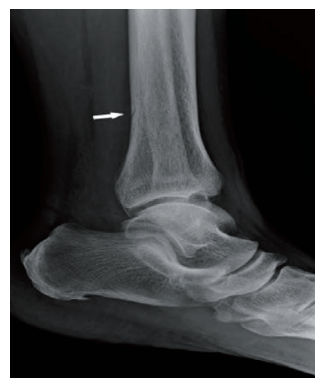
The lateral radiograph of the left tibia. The scan showed a cortical discontinuity on the posterior margin of the distal metaphysis (white arrow) (Feb 16<sup>th</sup>).
